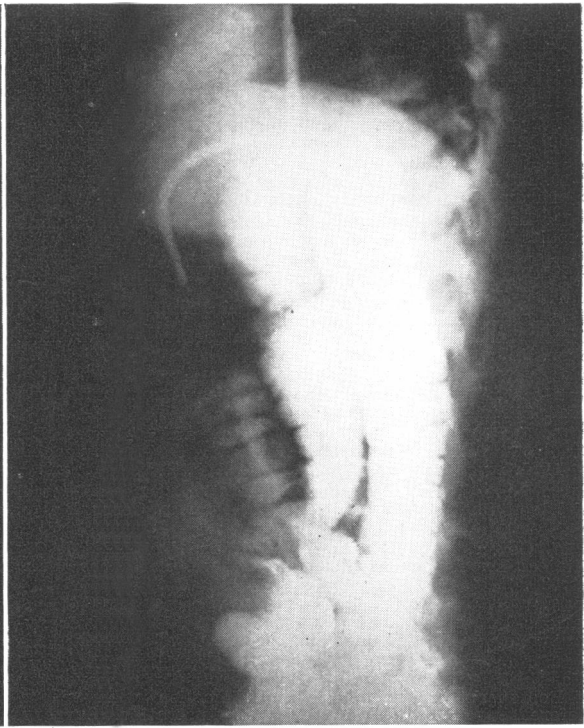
Lateral x-ray after barium enema. Note three different loops of colon in three different sagittal planes.
